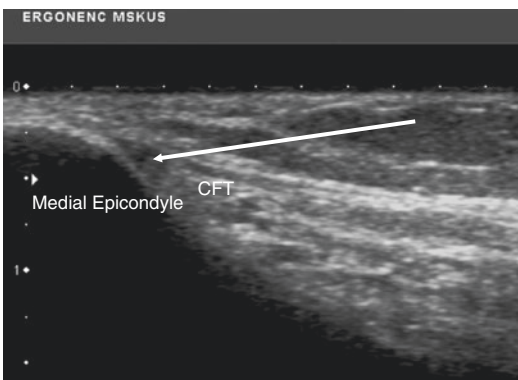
Long-axis sonogram of the common flexor tendon and medial epicondyle. Injection for the golfer's elbow with an in-plane approach
